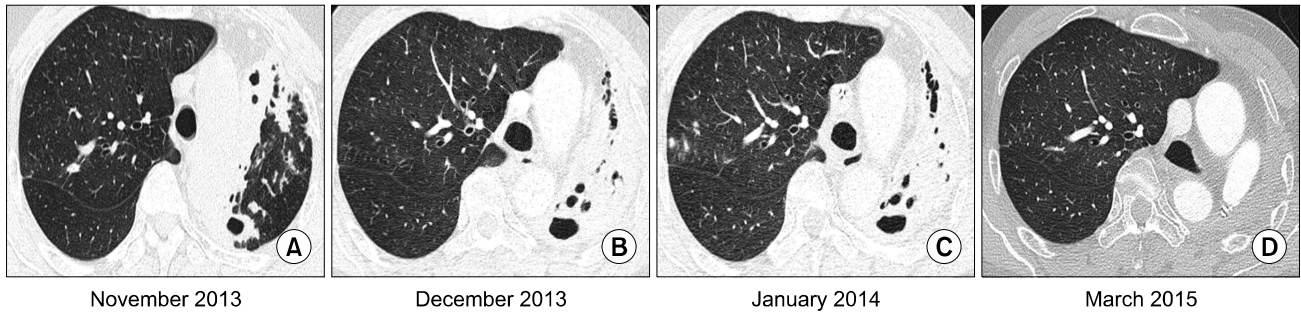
Serial changes in the same patient during therapy for Mab lung disease. (A) A CT scan 6 months after initial combination antibiotic therapy shows new peri-bronchial infiltration and cavities compared with a previous CT taken in June 2013. (B) A CT scan taken at the commencement of anti-tuberculosis and repeated anti-Mab therapy shows the destruction and collapse of the entire left lung. (C) A CT scan obtained after 4 weeks of full antibiotic therapy shows little change. (D) A chest CT scan taken 1 year after left pneumonectomy, followed by inhaled amikacin therapy, shows an improvement in the small bronchiolitis lesion in the right lung. Mab, *Mycobacterium abscessus subsp. abscessus*; CT, computed tomography.
